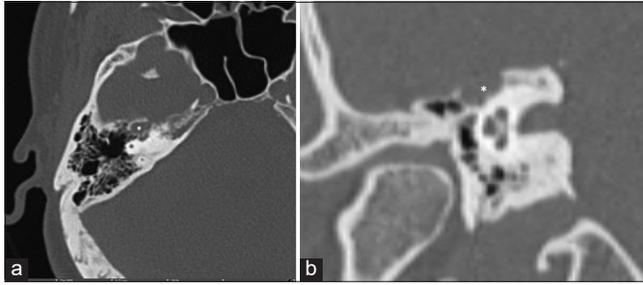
(a) Axial unenhanced computed tomography (CT) demonstrates a lucent expansile lucent lesion in the right petrous bone involving the right facial geniculate segment (white asterisk), (b) magnified coronal unenhanced CT image demonstrating a lucent expansile lucent lesion in the right petrous bone involving the right facial geniculate segment (white asterisk).
